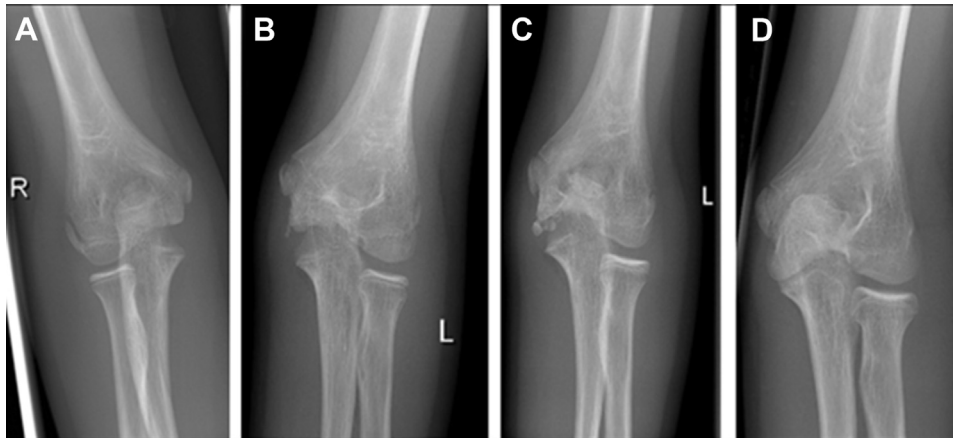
Sequential radiographs of 1 patient (study no. 14, female, presenting 7 months after ulnohumeral dislocation). (A) Unaffected side. (B) Baseline (age 8 years). (C) 1 year follow-up (age 9 years). (D) 4 years' follow-up (age 12 years).
